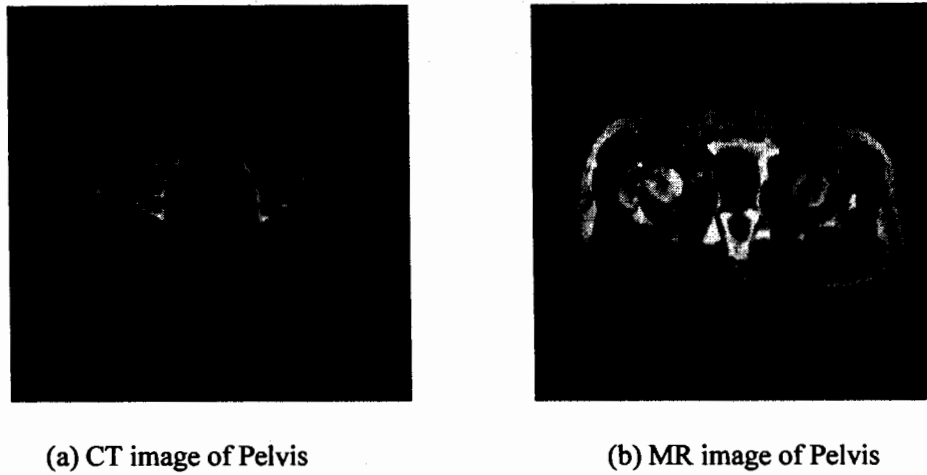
Dataset1-CT and MR images of Pelvis
